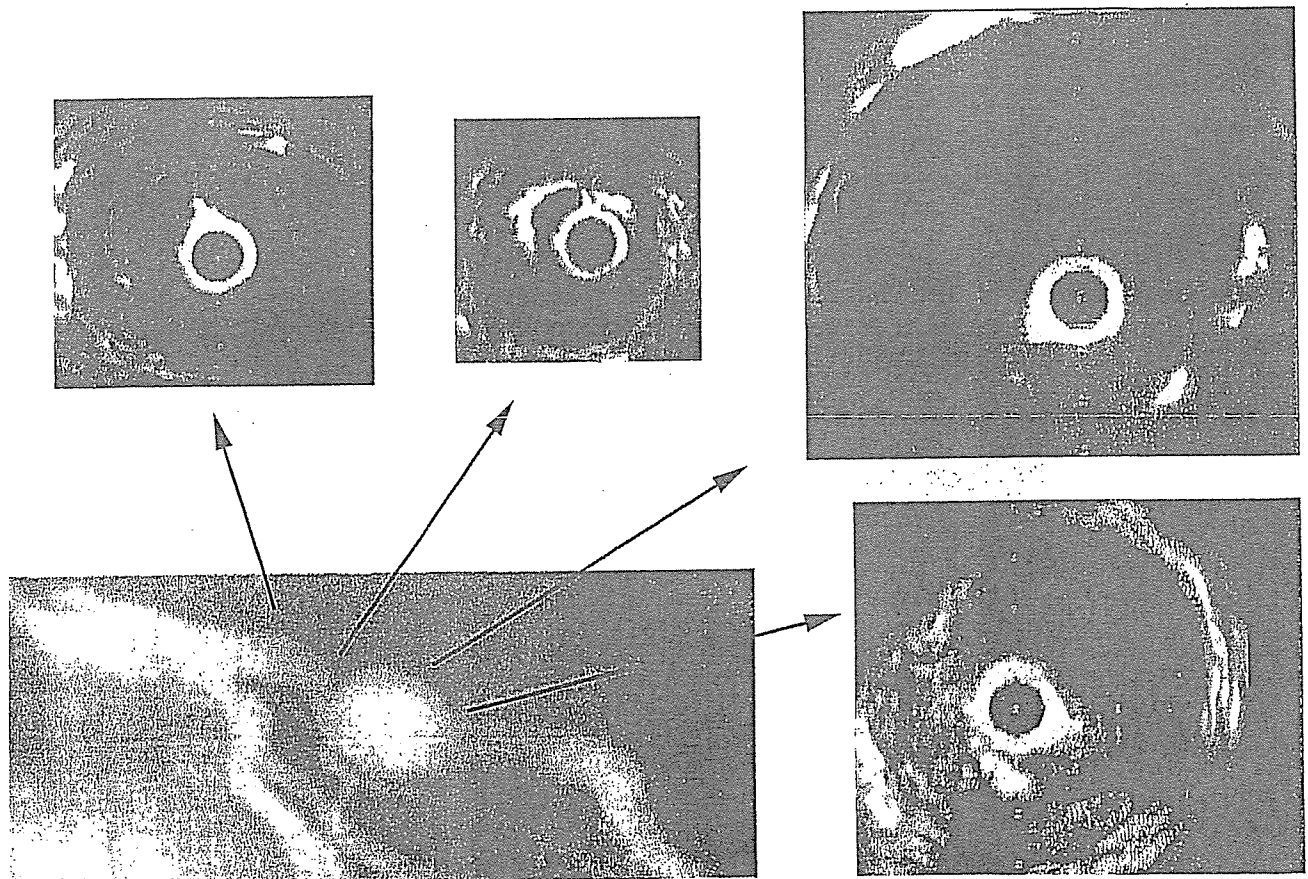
Intravascular ultrasound findings of a new aneurysm.
